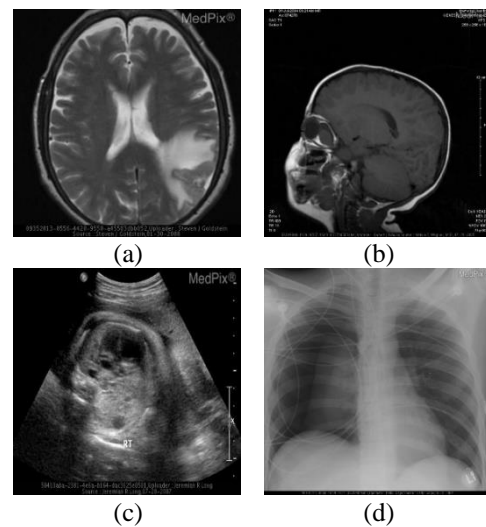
Four modalities of original medical image: (a) CT, (b) MRI, (c) US, and (d) X-Ray.
